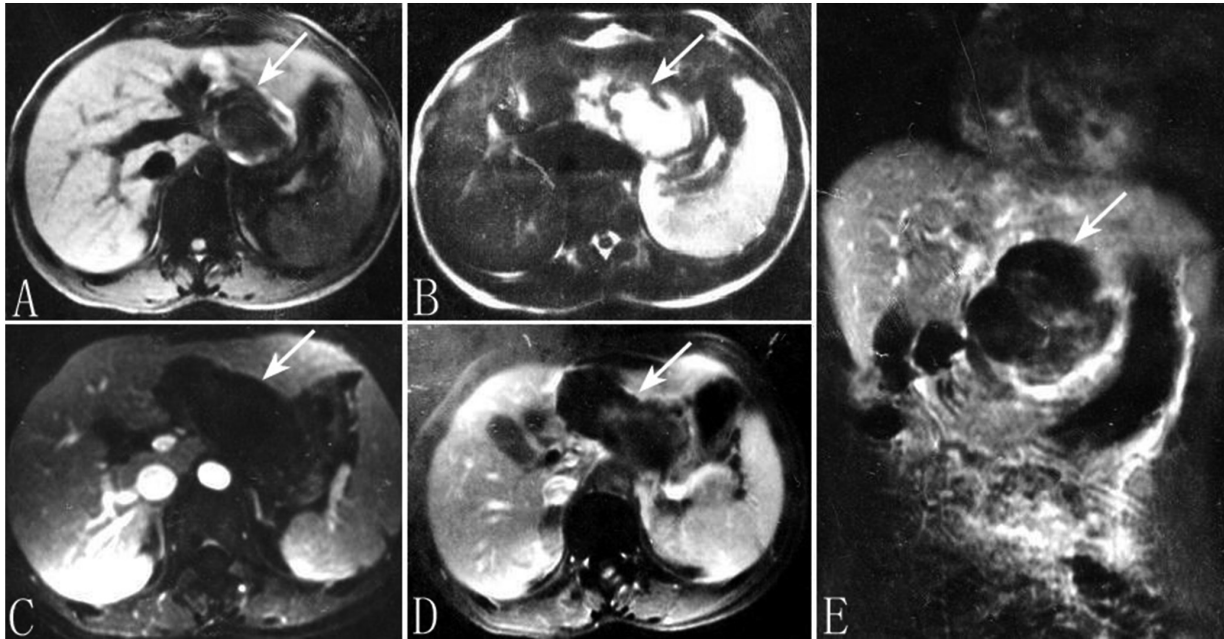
MRI findings. (A), T1WI reveals a round low signal focus (about 3×4.5 cm in size) between the inferior margin of the left hepatic lobe and lesser curvature of stomach. Most edges of the focus are clear. (B), T2WI reveals the focus appears to be obvious high signals, most of which are homogeneous. (C), The focus appears to be elliptical low signals with enhanced MRI during the arterial phase and there is no sign of intensification inside the focus and on the edge. (D), Slight intensification is displayed in the focus during the venous phase; a bit of ring-shaped intensification may be seen on the edge of the right frontal. (E), Coronal scan clearly reveals that the disease takes on a round-like low signal with a slight non continuous ring-like intensification and with slight irregular intensification inside.
